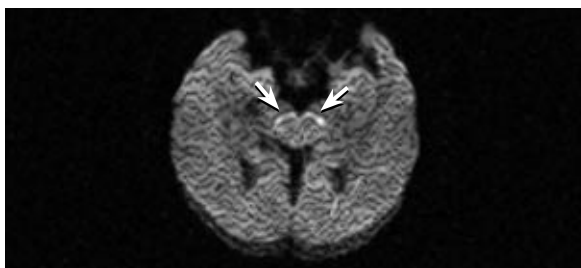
Axial diffusion-weighted MR image demonstrates linear hyperintense signal involving the substantia nigra compatible with restricted diffusion.
